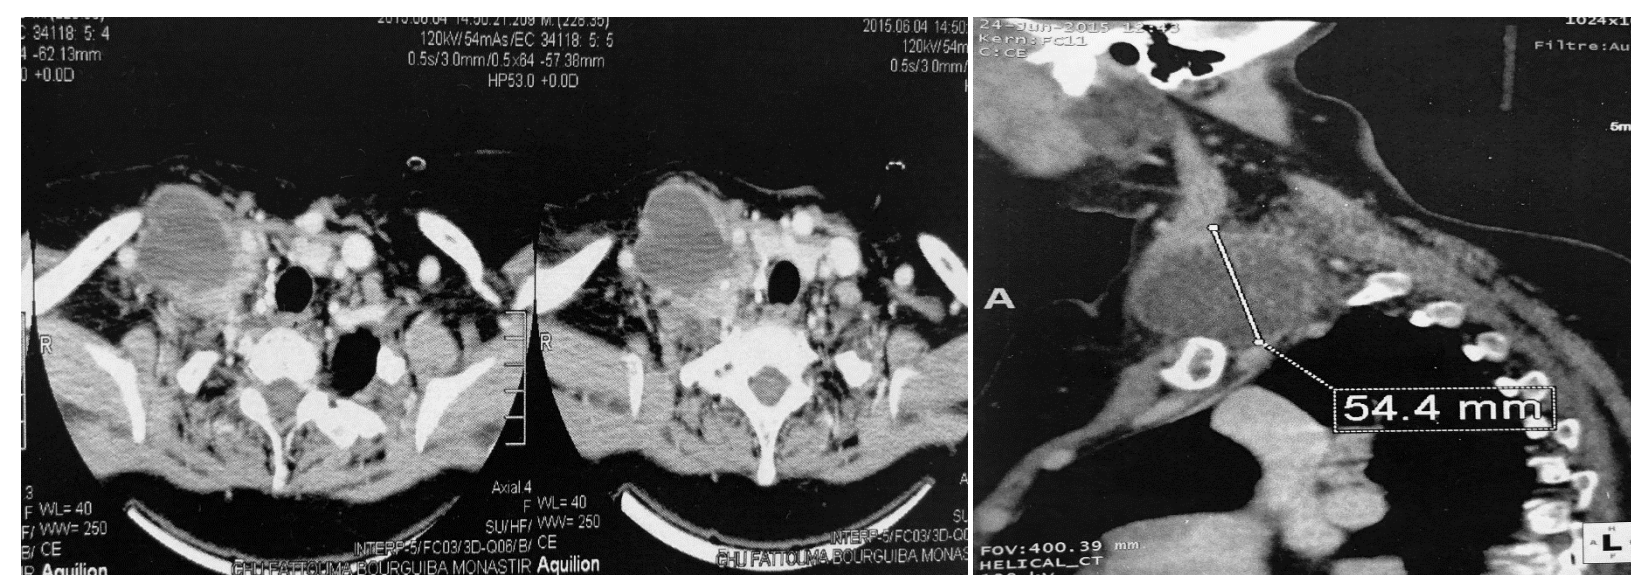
CT scan showing a left supraclavicular cystic lymph node
